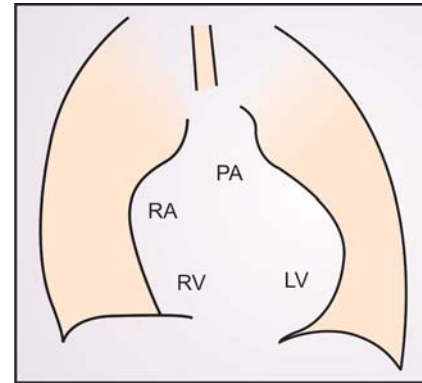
Classical X-ray appearance of an ASD
